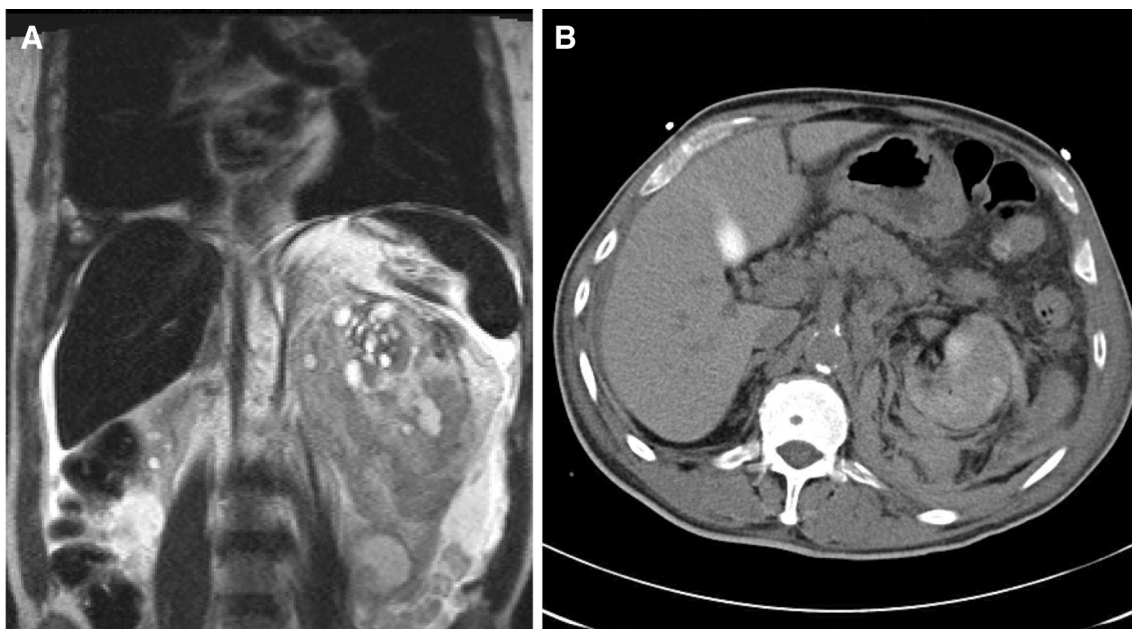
63-year-old man with chronic renal failure, on hemodialysis found to have left renal mass on prior CT. Patient had undergone percutaneous US/CT guided biopsy and ablation. A Delayed MRI was obtained given the patient's unstable hemodynamics in the postprocedural recovery room. Coronal T2 HASTE image shows 10 × 12 cm left sided
